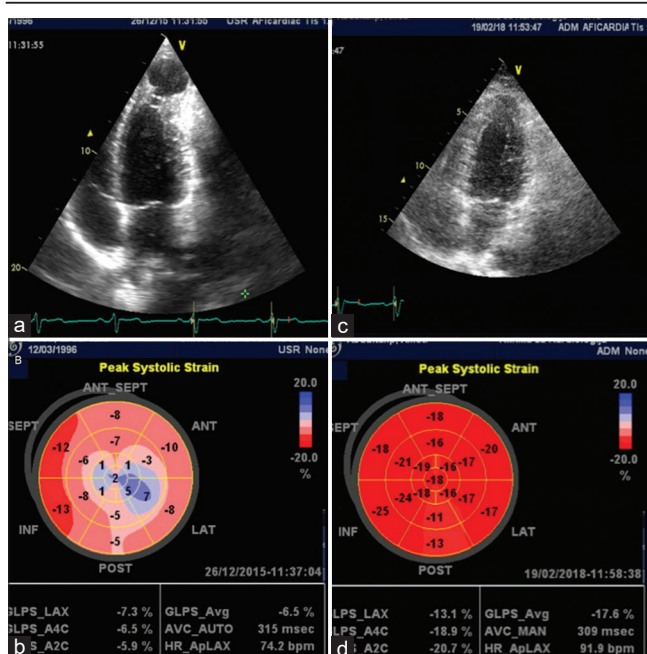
(a) Four-chamber view of transthoracic echocardiogram demonstrating apical aneurysm, (b) Bulls eye-reduced global longitudinal strain in the presence of apical aneurysm, (c) Four-chamber view showing condition after aneurysmectomy, (d) Bulls eye-normal global longitudinal strain after aneurysmectomy
